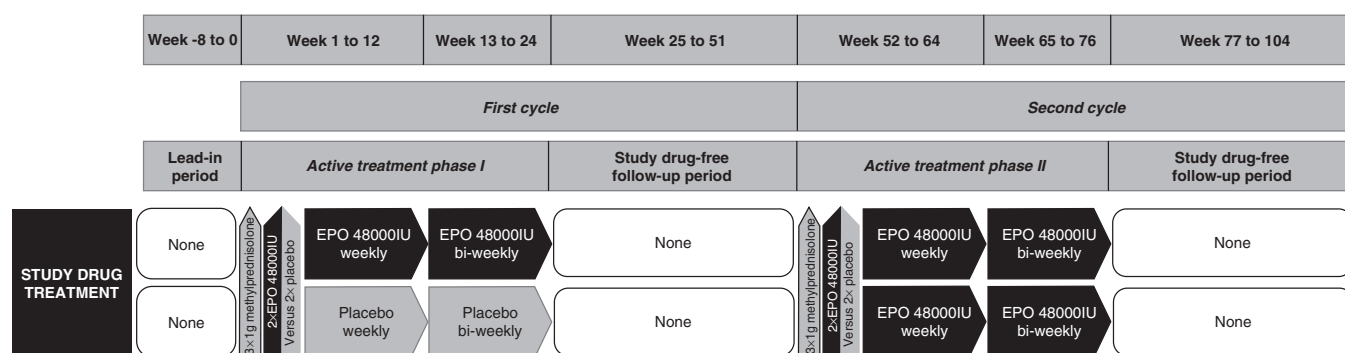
Investigational drug treatment design of ‘recombinant human erythropoietin as a neuroprotective/-regenerative treatment of chronic progressive multiple sclerosis (EPO-MS): a double-blind, placebo-controlled, randomized phase IIb trial’. Patients start with an 8-week lead-in period, allowing extensive, repeated rating of baseline performance (estimation of fluctuations) ended by a short, dense ‘start-up assessment’ (including clinical, neurophysiological, neuroophthalmological, MRI, cognitive, laboratory assessments). Treatment initiation with 3 × 1000 mg methylprednisolone given on 3 consecutive days, and EPO (48,000 IU; in additional dose-finding treatment arms alternative dosing with 32,000 and 16,000 IU, respectively) vs placebo on days 2 and 3 of methylprednisolone treatment follows. Patients then receive EPO/placebo weekly for 12 weeks, biweekly for another 12 weeks and undergo a 6-month post-treatment observation period with visits every 6 weeks. In the second year all patients are switched to verum following the same schedule until individual study end after 26 months (2 + 12 + 12).
